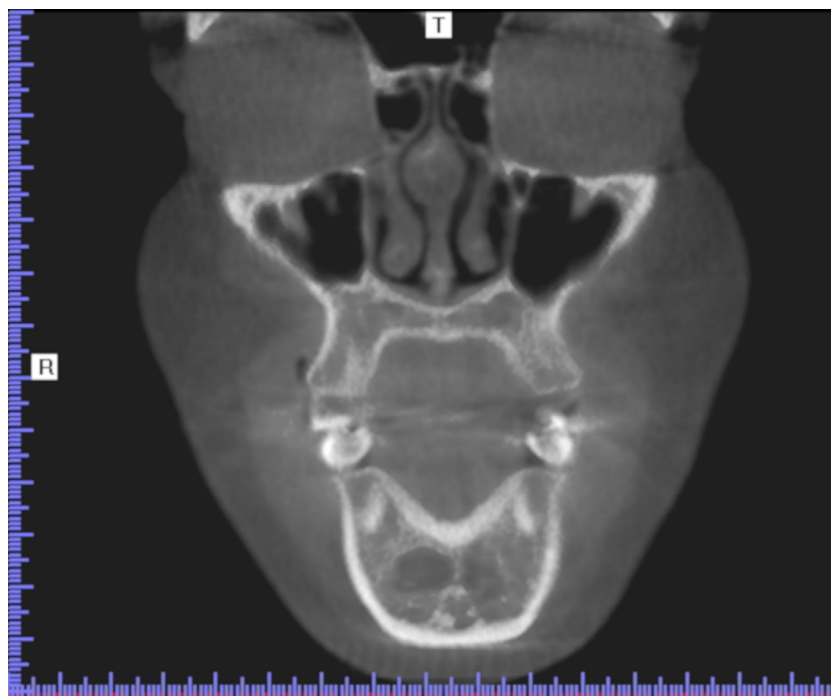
Coronal view of the cone beam computed tomography (CBCT) image demonstrating a similarly well-circumscribed radiolucency observed in the panoramic radiograph.
